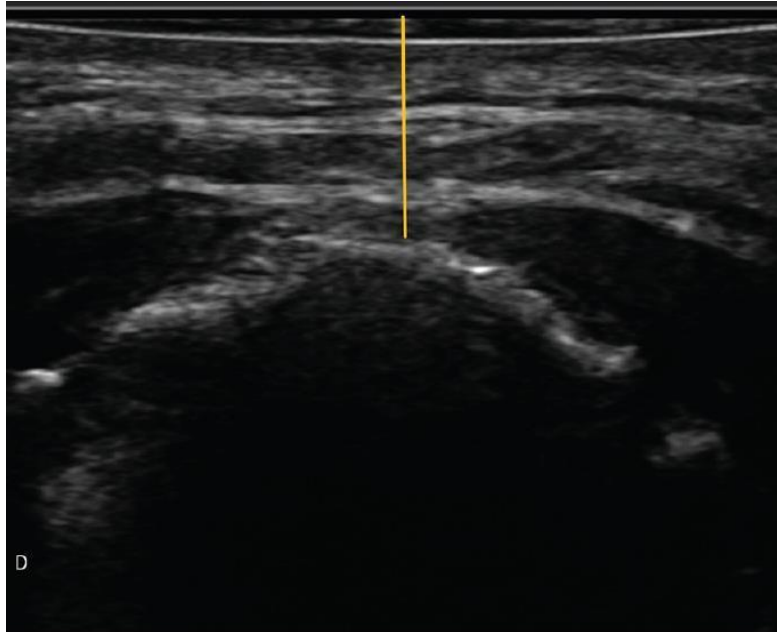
Distance from skin to hyoid bone measured with ultrasound
